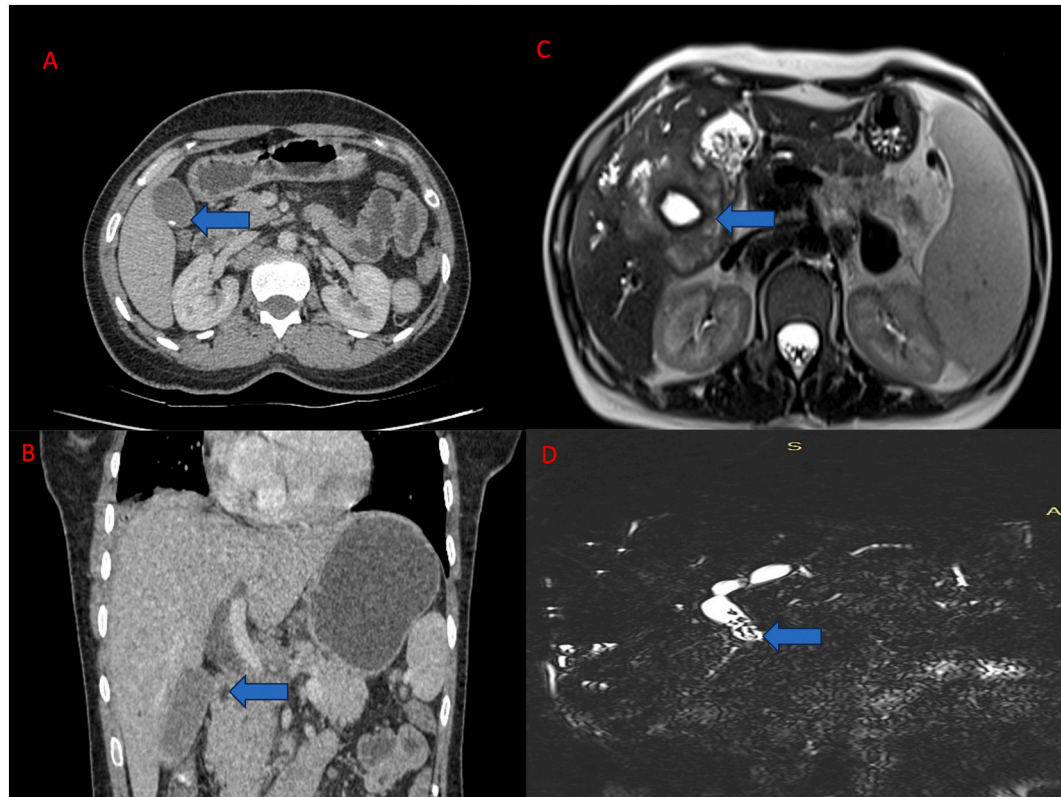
A, B- triphasic contrast-enhanced computed tomography showing a distended gallbladder with thick walls containing calculus in the lumen and a dilated common bile duct with distal abrupt tapering indicative of distal CBD stricture. C, D- magnetic resonance cholangiopancreatography showing a mass-like irregular GB wall thickening with infiltration of the adjacent liver parenchyma with bilobar moderate intra-hepatic biliary dilatation, splenomegaly and dilated CBD with multiple intraluminal filling defects.
